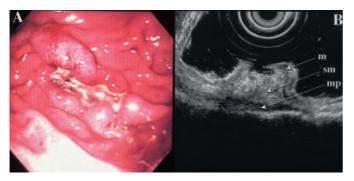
The second gastroscopic examination performed 5 days after the first one; (A), the submucosal tumor-like lesion seen on the first examination had disappeared and was replaced by a large ulcer on an edematous enlarged gastric fold. (B), Endosonographic examination of the ulcerated lesion showed a heterogeneous thickening of the third and the superficial part of the fourth echo-layers corresponding to the submucosa and muscularis propria, respectively. m, mucosa; sm, submucosa; mp, muscularis propria.
